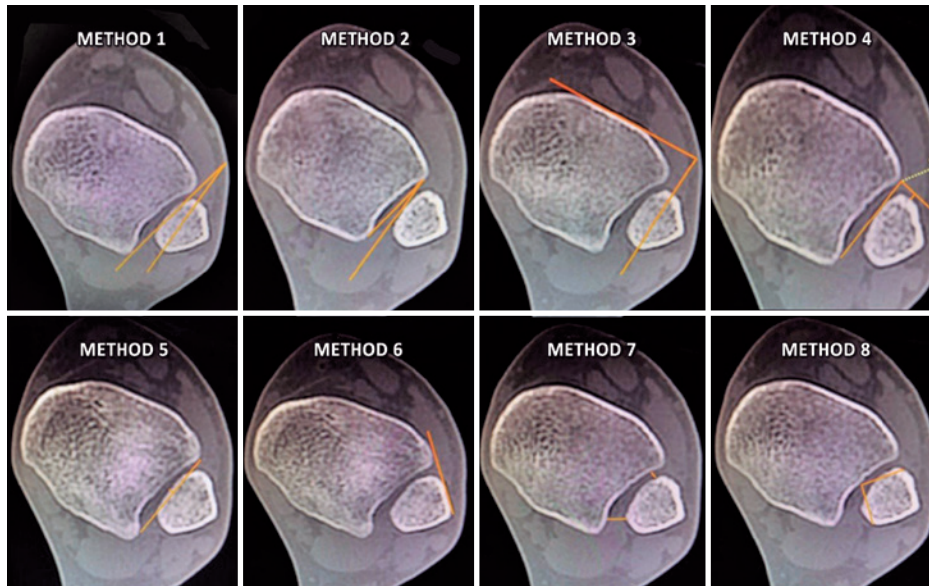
Computed tomographic measurement methods in the axial plane at a distance of 1 cm from the ankle joint.
